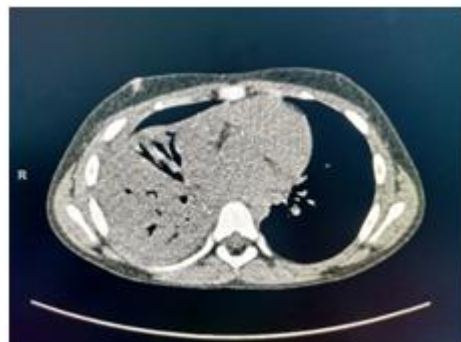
CT CHEST evidence of homogenous soft density 11.3*6.5mm is seen impacted at the root of the right lower bronchus with consolidation collapse of the lower lobe segment with air bronchogram
